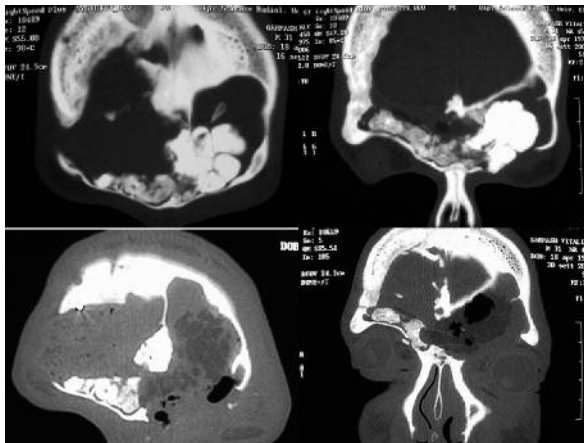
Upper row: preoperative CT coronal bone scans showing the extension of the lesion. Lower row: postoperative CT coronal bone scans showing the complete removal of the left orbito-ethmoidal lesion after combined endoscopic trans-nasal ethmoidal and supraorbital neuronavigation-assisted approach.
